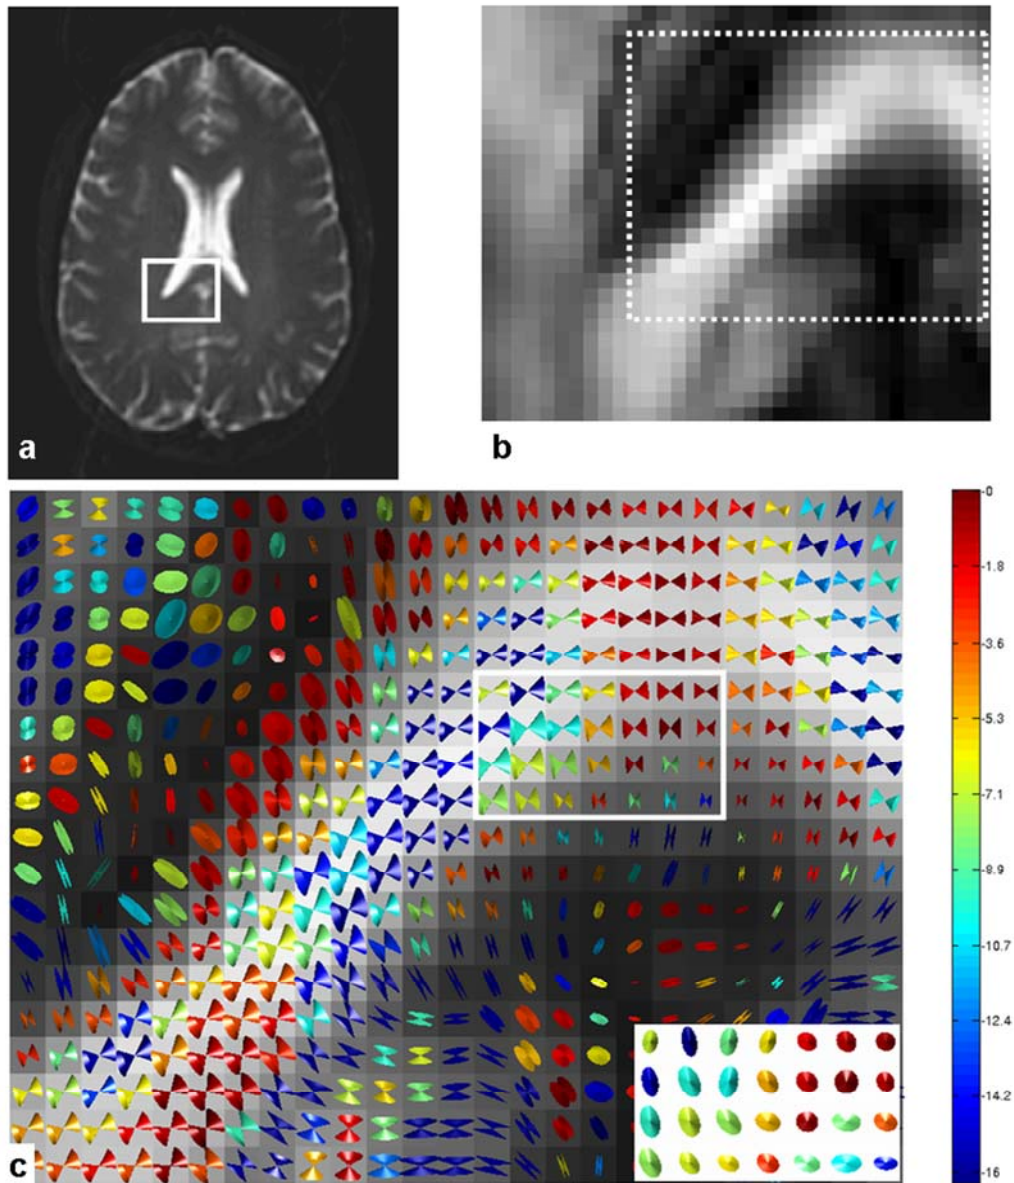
A T2-weighted image (a) showing an ROI and its FA map (b). The white dotted area in (b) is used in (c) for CU visualization. The CUs (using 6 averages, 200 bootstrap samples) are color coded according to base 10 logarithm of the p-value from the test for zero eccentricity. Low probability of circularity (zero eccentricity) is shown as dark blue, while high probability is shown as red (c). The base of each cone in the rectangular region in (c) is shown in the local \mathbf{v}_2 (horizontal in the inset) - \mathbf{v}_3 (vertical) plane at the lower right corner in (c). Those cones are uniformly scaled for clear visualization.
